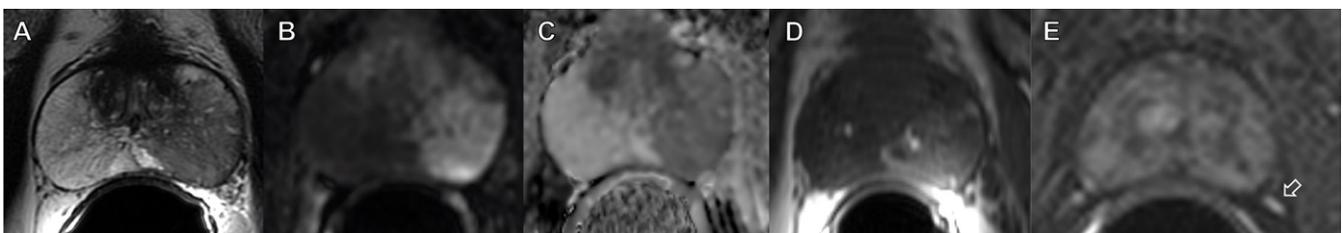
Example of a scanner with an endorectal coil whose image quality was improved after feedback. Images from phase I (A–D) show axial T2-weighted imaging (A), high b value ($b = 1400$ sec/mm²) (B), and apparent diffusion coefficient map (C) of optimal diagnostic quality, but dynamic contrast-enhanced sequences (D) are not fat suppressed and show artifacts. Feedback for these sequences was provided, and the resubmitted dynamic contrast-enhanced images from phase II (E) show adequate fat suppression and clearly visible capsular vessels (arrow).
